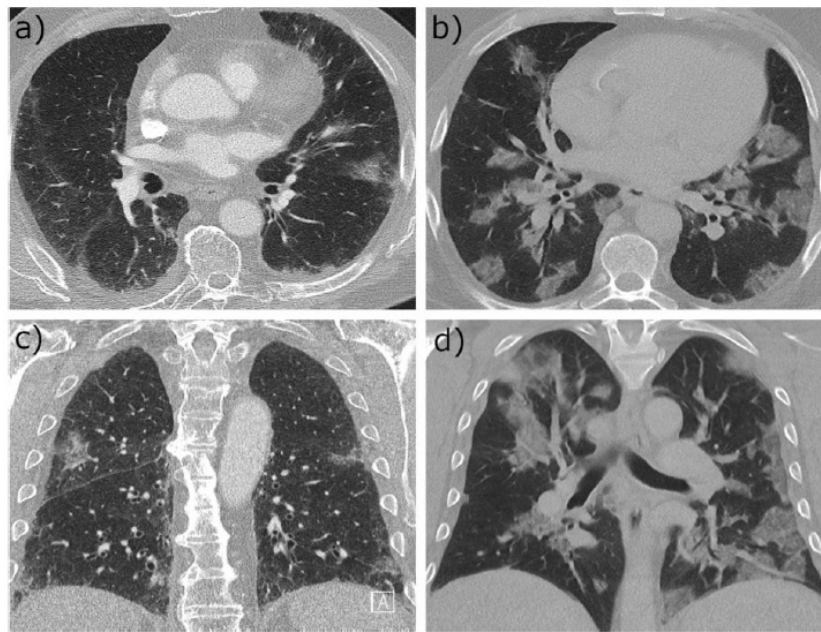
Representative axial (a-b) and coronal (c-d) slices of chest computed tomography (CT) images of unvaccinated patients are shown. Patients 1 (a & c) and 2 (b & d) show air bronchogram, crazy-paving pattern, ground-glass opacities, and high expansion of pulmonary patterns. Patient 1 was 64 years old and achieved a CT severity score of 5. Patient 2 was 48 years old and achieved a CT severity score of 9.
